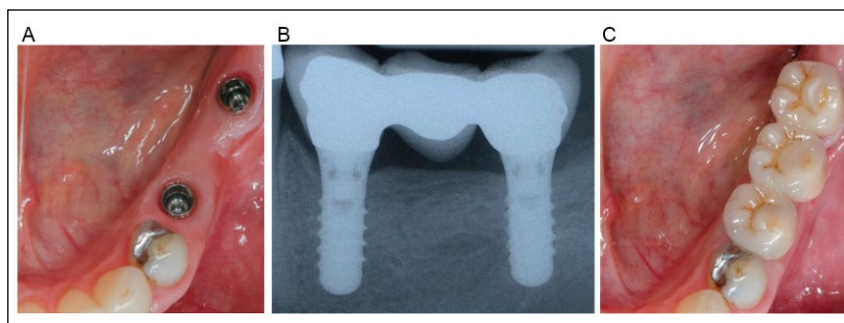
Increasing subjective chewing comfort in a partially edentulous patient. (A) Clinical situation after implant placement in a free-end situation. Implants were placed at a distance of 5 mm from the distal surface of tooth 34 (replacement of tooth 35) and at a distance of 19 mm (replacement of tooth 36/37) to incorporate a 3-unit bridge. (B) Radiographic evaluation after 5 y. Minimal bone resorption (<1 mm). (C) Five years after incorporation of an implant-supported 3-unit fixed dental prosthesis. *Courtesy of Prof. Dr. G.E. Salvi, University of Berne.*
